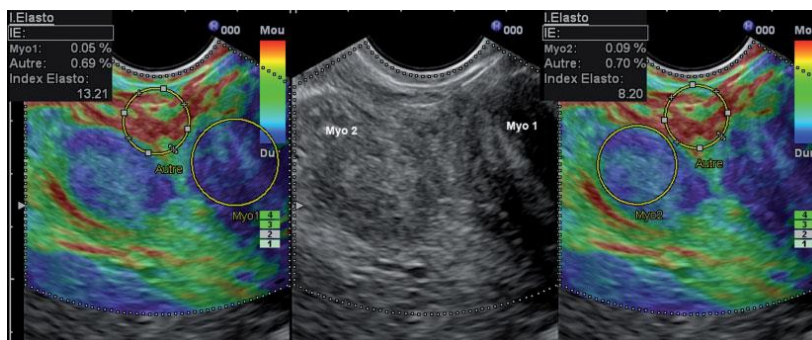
Real-time elastosonography images of the two fibroids shown in Figure 1. The strain ratio is evaluated by comparing the mean strain in a region of interest centered on the myoma, with the mean strain in a region of interest in the surrounding myometrium close to the probe. The fibroid
